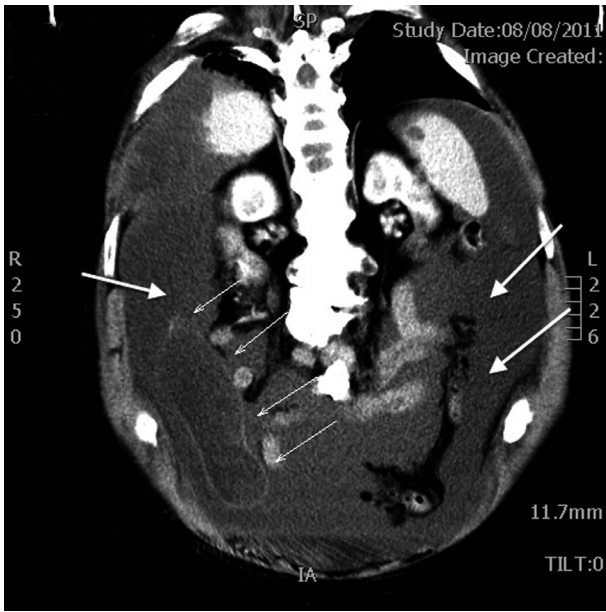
Coronal CT scan. The thin arrows highlight the appendiceal mucocele. The thick arrows highlight the ascites.
